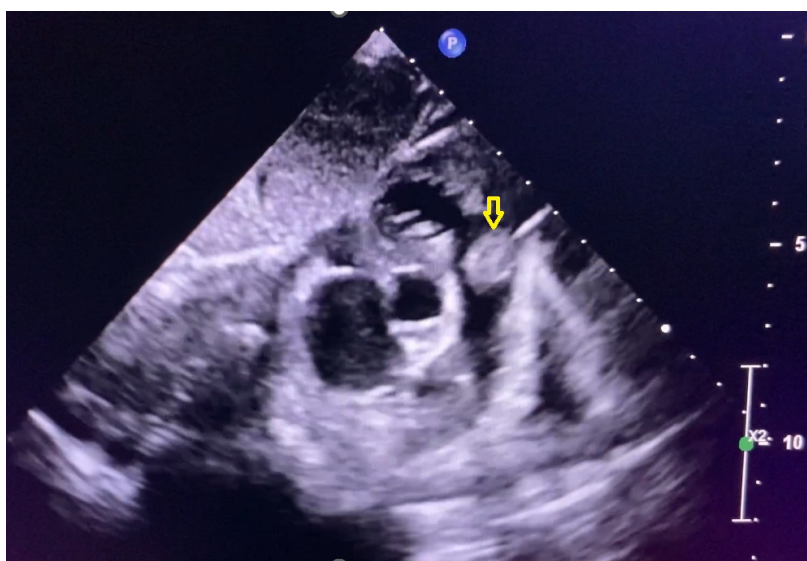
Representative transthoracic echocardiographic image from Case 1 obtained in the subcostal short-axis view, demonstrating an intracardiac fibroma (arrow) arising from the right ventricular septum and causing right ventricular outflow tract obstruction.
